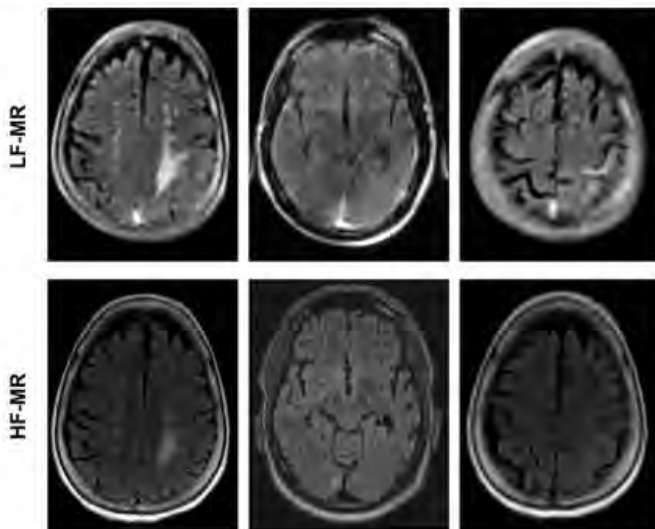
Representative ARIA-E on FLAIR images at low field (LF) and high field (HF) in patients with Alzheimer's disease (AD) received lecanemab.
